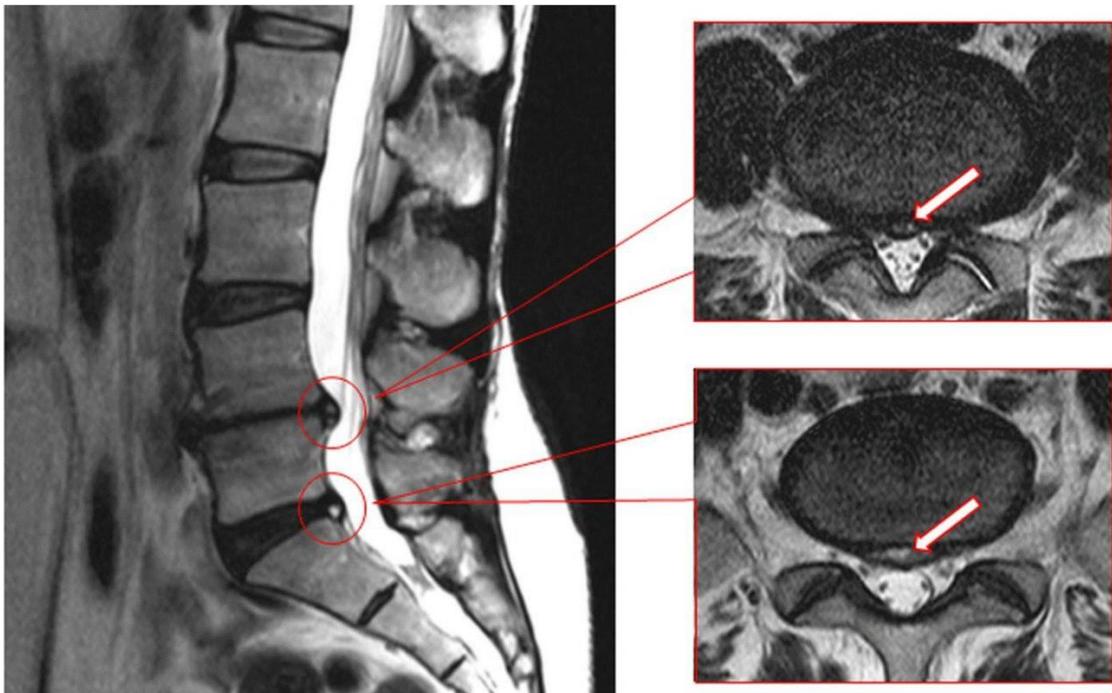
Disc bulge and herniations (white arrow) were diagnosed when the annulus was bulged beyond the posterior vertebral border of the disc in sagittal T2 MRI images. Annular tears/ high-intensity zones were defined as focal areas of high signal intensity on axial T2 images near the posterior disc annulus (white arrow).⁽¹³⁾
